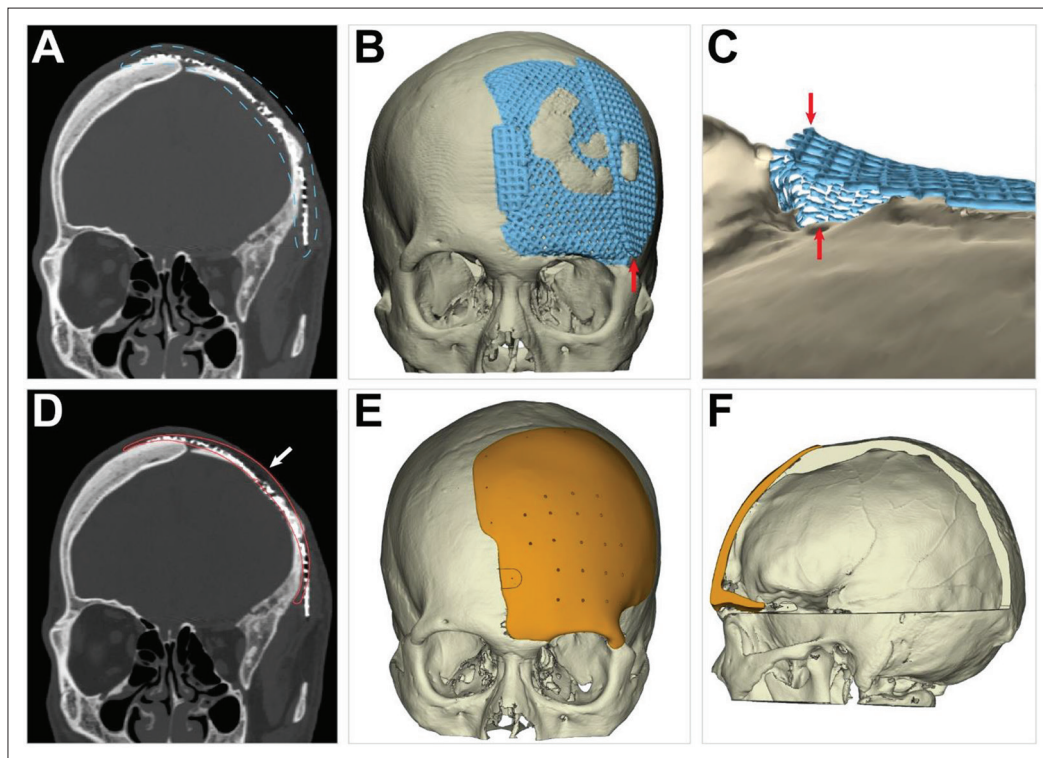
Three-dimensional reconstruction of head CT before surgery and computer design of PEEK implant. (A) Head CT shows the defect of the left frontal bone and the imaging performance after cranioplasty with titanium mesh. (B) The 3D reconstruction of head CT shows the anatomical relationship between the titanium mesh and the skull from the coronal views, and the protruding part of the titanium is seen (indicated by red arrow). (C) The 3D reconstruction of head CT from the horizontal direction shows that the protruding part of the titanium and the gap between the titanium mesh and the skull. (D) Designing the scope of PEEK implants from sagittal CT (indicated by the white arrow). (E) Three-dimensional model of the designed PEEK implant. (F) The 3D reconstruction from coronal CT of the head shows thickness inhomogeneity of the skull and changes in the curvature of PEEK implants.
